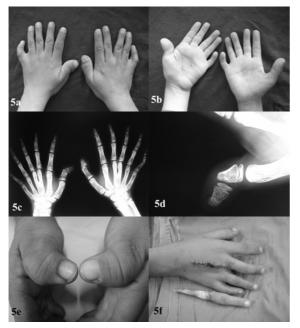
Central polydactyly with thumb clinodactyly. a).Dorsal view. b).Palmar view. It is difficult to discriminate the duplicated finger. c).Radiographs show the splitting of third metacarpals without evidence of distal SD. Note the clinodactyly of the right thumb and camptodactyly of both little fingers. d). Severe clinodactyly in thumb because of delta phalanx. e).Thumbs are bilaterally clinodactylized in some patients. Note the cone epiphysis in the distal phalanx. f). After resection
